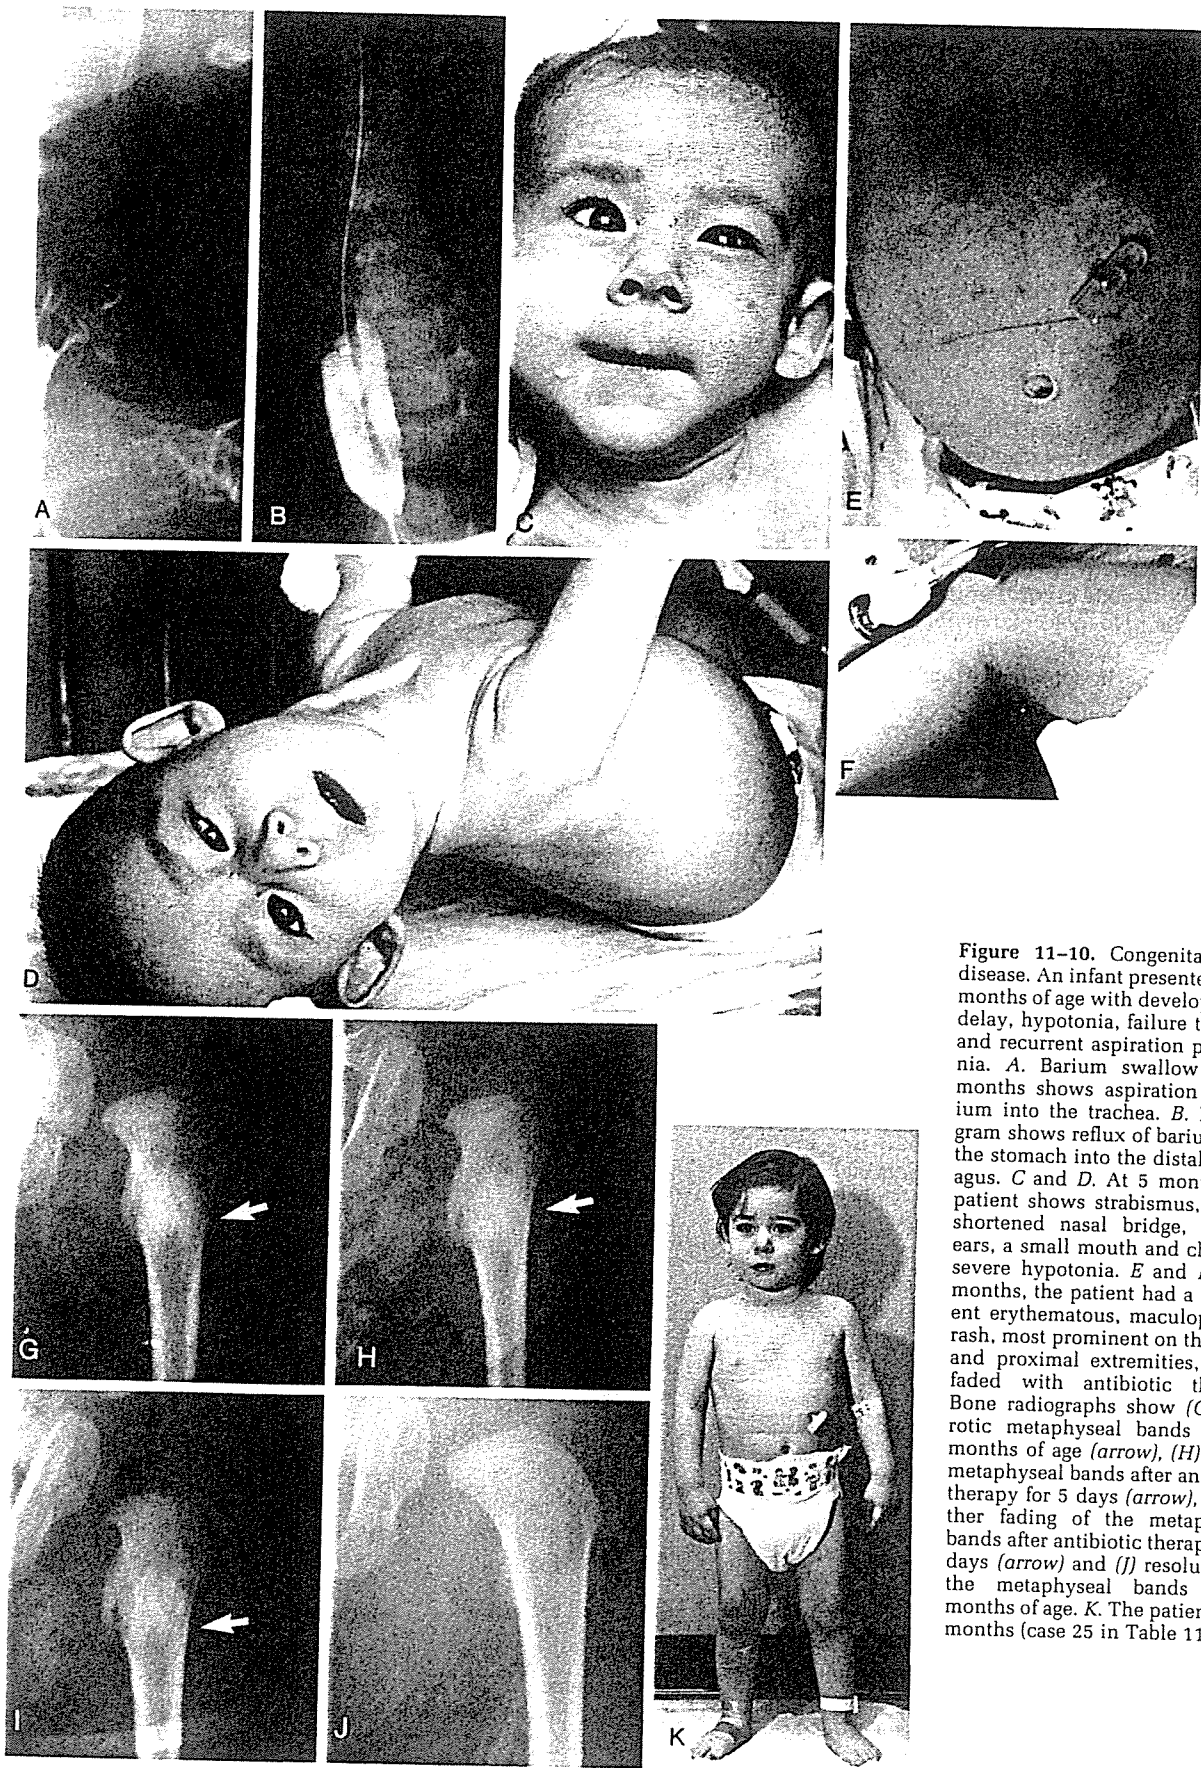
Congenital Lyme disease. An infant presented at 2½ months of age with developmental delay, hypotonia, failure to thrive and recurrent aspiration pneumonia. A. Barium swallow at 2½ months shows aspiration of barium into the trachea. B. Esophagram shows reflux of barium from the stomach into the distal esophagus. C and D. At 5 months, the patient shows strabismus, a foreshortened nasal bridge, cupped ears, a small mouth and chin and severe hypotonia. E and F. At 5 months, the patient had a persistent erythematous, maculopapular rash, most prominent on the trunk and proximal extremities, which faded with antibiotic therapy. Bone radiographs show (G) sclerotic metaphyseal bands at 2½ months of age (arrow), (H) fading metaphyseal bands after antibiotic therapy for 5 days (arrow), (I) further fading of the metaphyseal bands after antibiotic therapy for 6 days (arrow) and (J) resolution of the metaphyseal bands by 5 months of age. K. The patient at 25 months (case 25 in Table 11-8).
